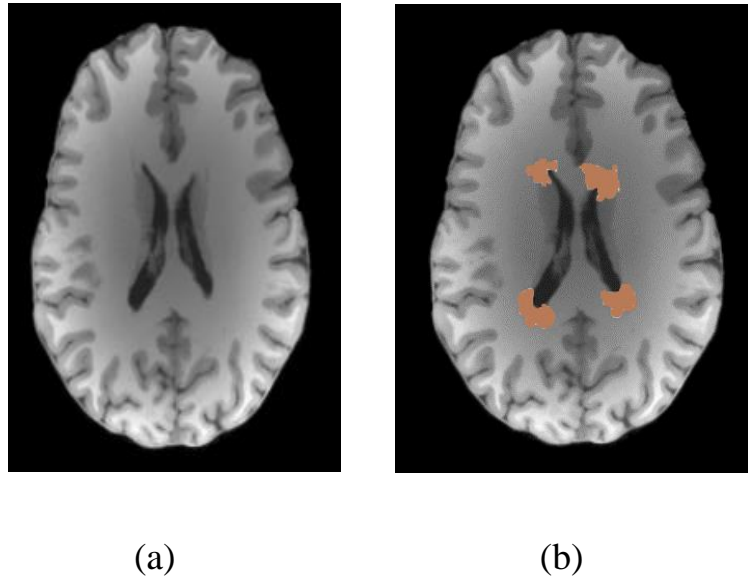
(a) MRI T1 brain image of a healthy patient, (b) lesions are added artificially to mimic the MS lesions.
